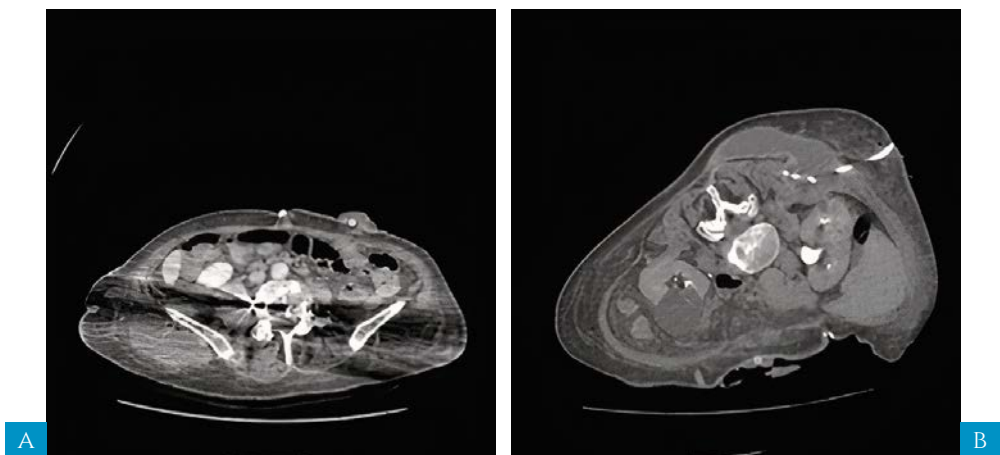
a, b: Abdominal CT
